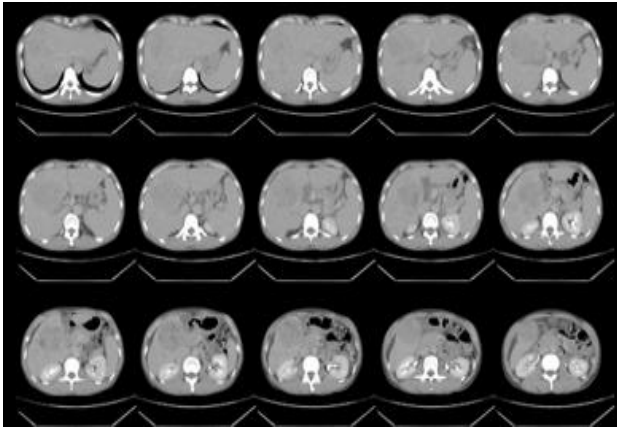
Subsequent three-phase whole abdominal CT showed a right hepatic lobe mass consistent with advanced HCC. The patient was then diagnosed with hepatomegaly due to right lobe liver tumor suspicious for malignancy.
